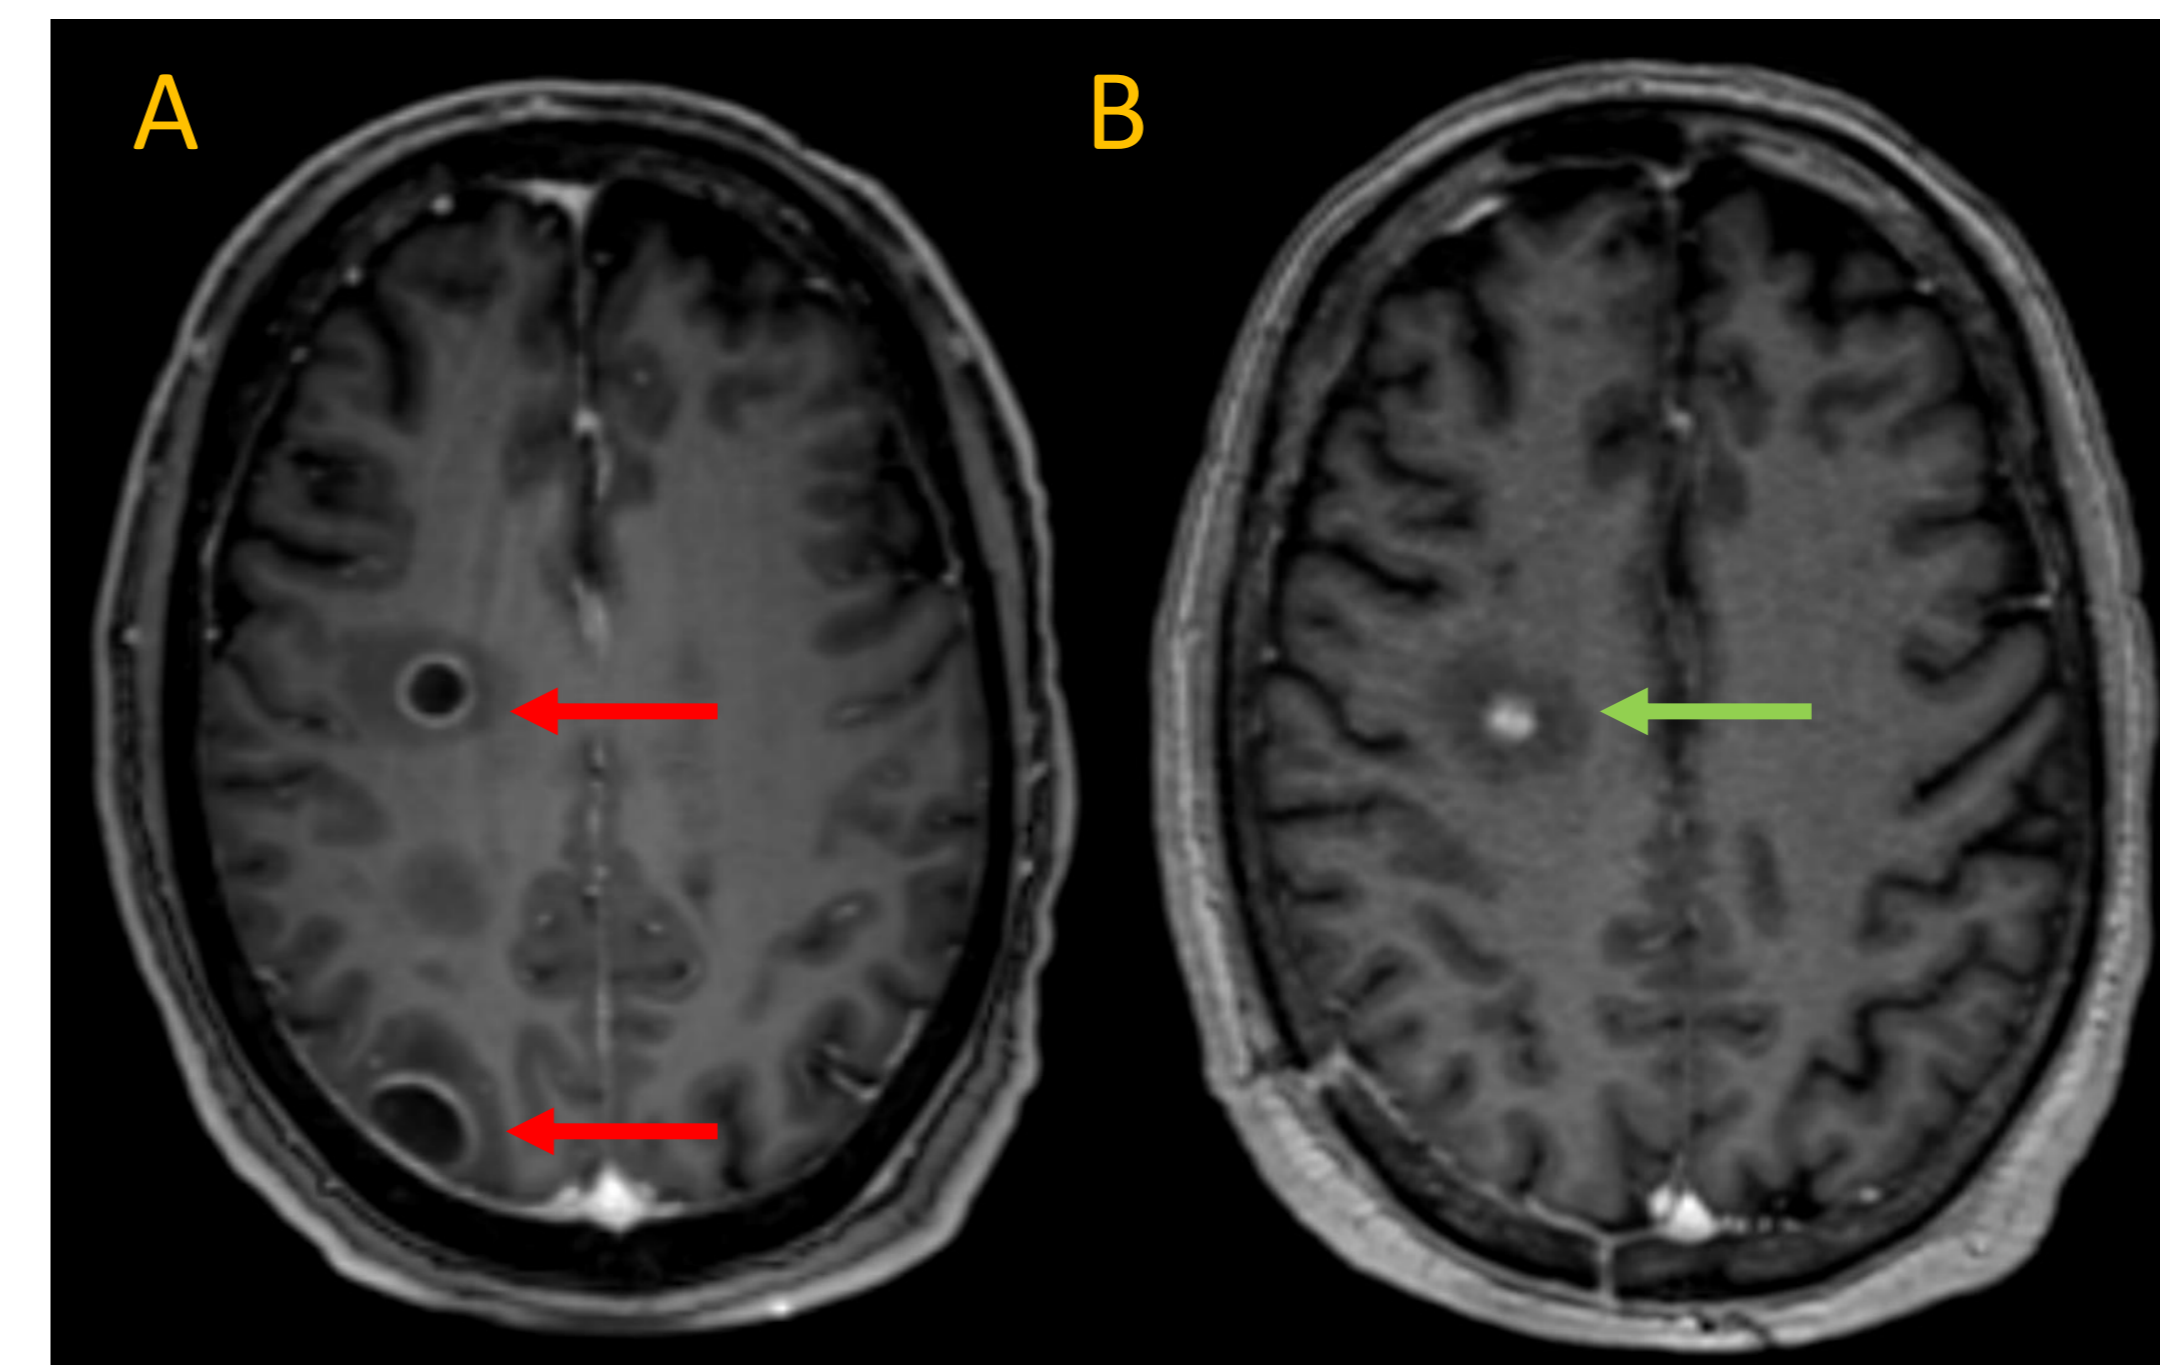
Brain MRI (contrast-enhanced T1-weighted sequence) at diagnosis (A) and after 8 weeks (B). Two brain abscesses were initially found (red arrows). The control MRI showed a slight contrast enhancement of one BA (green arrow), and disappearance of the second BA.
